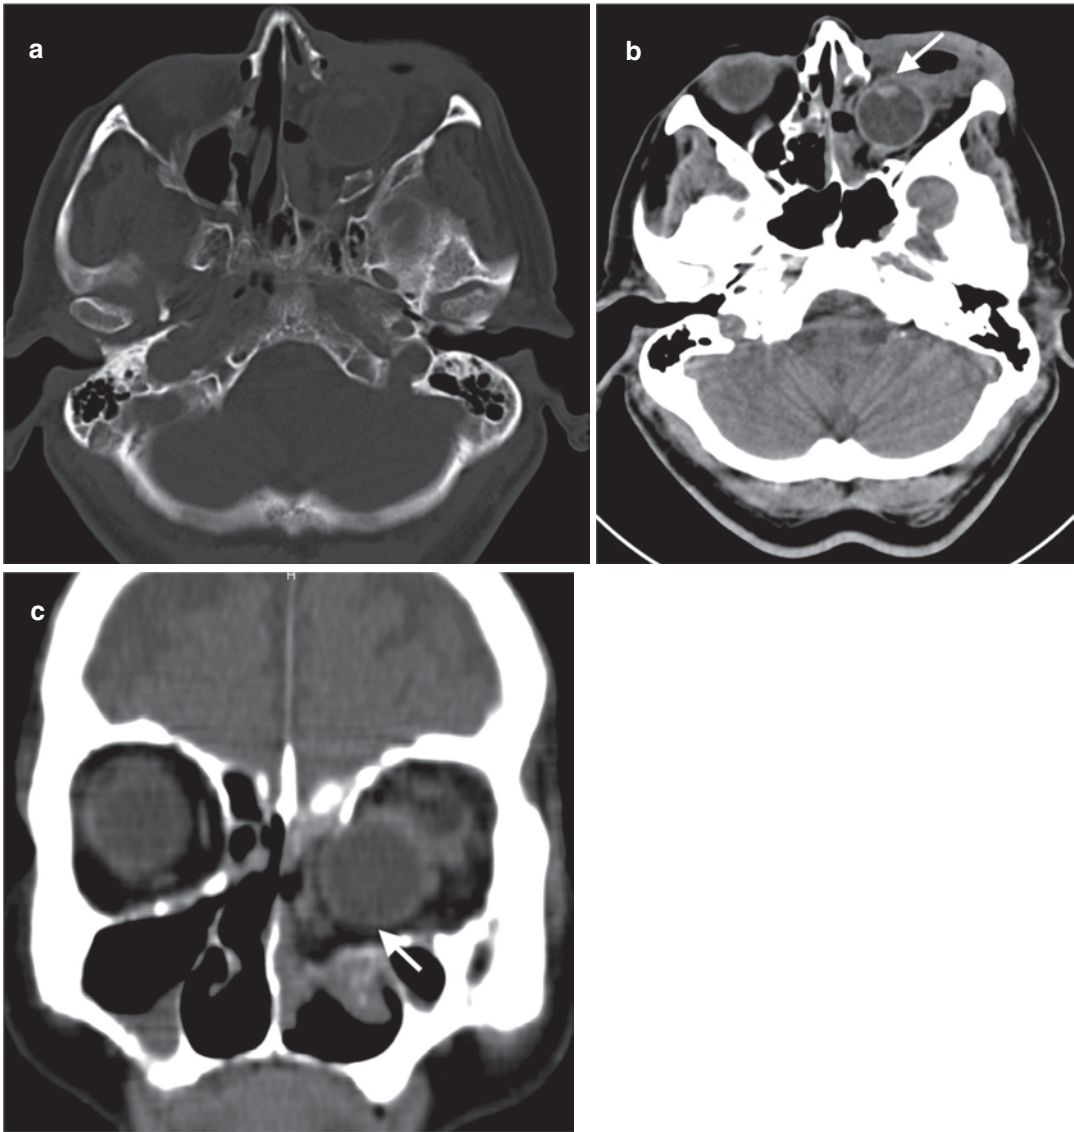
Internal globe herniation secondary to blow-out fracture in a 75-year-old man. (a) A blow-out fracture with a large defect of left orbital wall is seen at bone window axial CT image. Axial (b) and coronal (c) CT images
